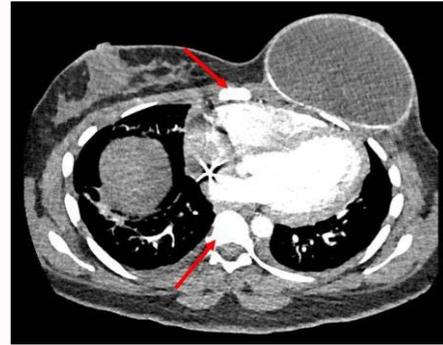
Chest CT at 3wks postpartum showing interval resolution of lytic lesions in vertebral bodies.
